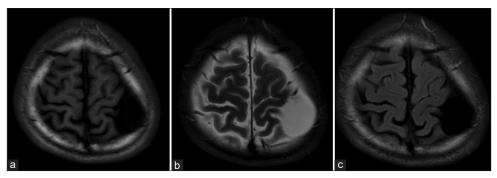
T1- (a), T2- (b), and fluid-attenuated (c) magnetic resonance images on admission, showing an extra-axial cystic lesion in the left convexity. No cerebral contusions or hemorrhages are visible.
